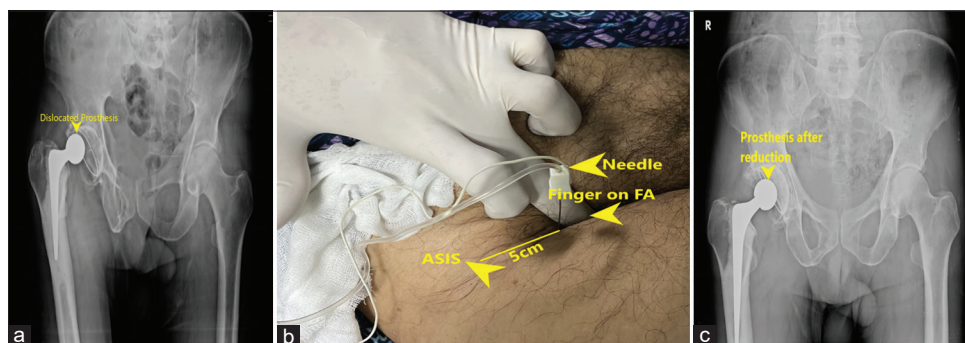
(a)- X-ray showing right side dislocated hip prosthesis, (b)- 100 mm blunt tip needle entering perpendicularly 5 cm medial to ASIS till bony contact (superior pubic ramus) while fingers of other hand on FA. ASIS-anterior superior iliac spine, FA-femoral artery, (c)- check x-ray after reduction
